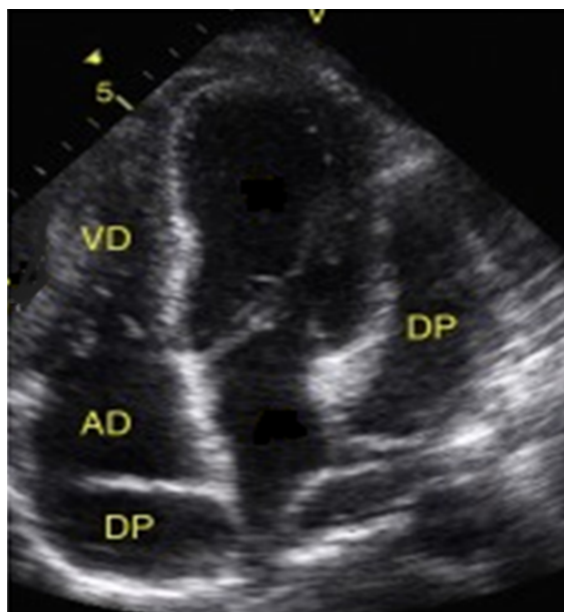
Transthoracic echocardiogram showing mild pericardial effusion in the posterior wall of the right atrium and moderate adjacent pericardial effusion adjacent to the left cavities. AD: right atrium; RV: right ventricle; PD: pericardial effusion. Source: Document obtained during the study.
